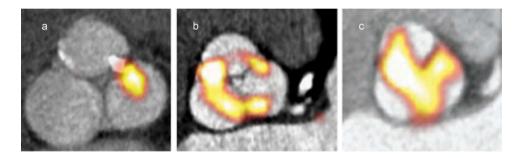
18 F-Fluoride PET image fused with the CT scans demonstrating increasing severity of abnormal uptake (From panel a to c), indicating regions of calcification activity. Courtesy of Drs. Tania Pawade and Marc Dweck.
